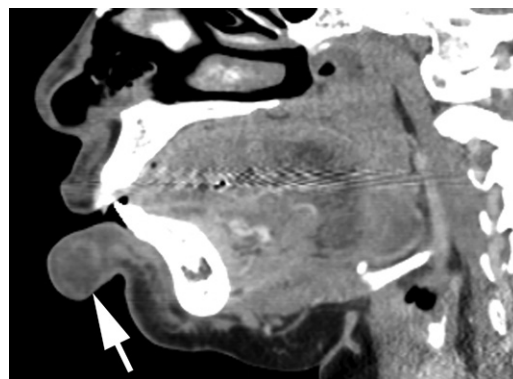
Sagittal contrast-enhanced CT image in a 45-year-old woman shows edema of the lower lip (arrow), consistent with angioedema.
